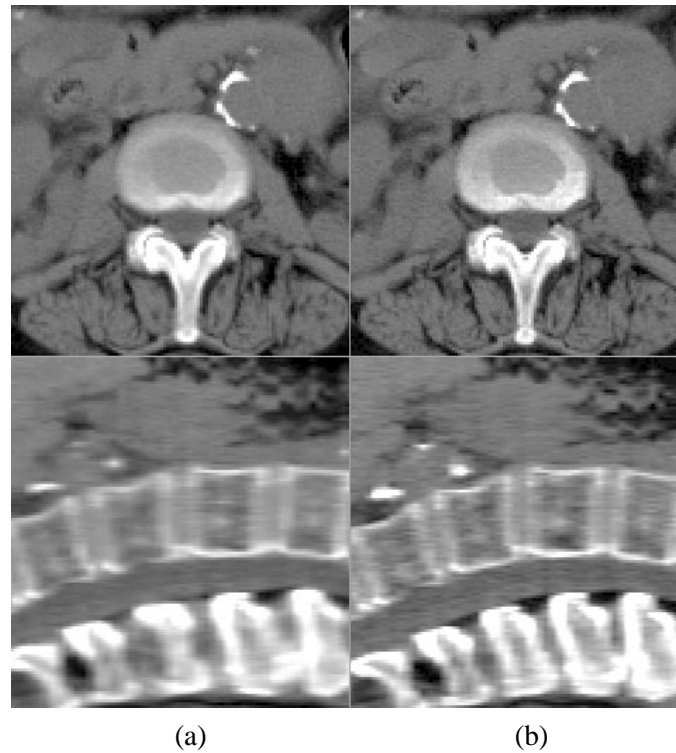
Axial and sagittal sections through the deformed CT volume (a) and through the pre-operative CT volume (b). The L1, L2, L3 and L4 vertebrae are shown. Note that the vertebrae have moved as rigid bodies. The pre-operative CT volume shows more extension in the spine than the deformed volume.
